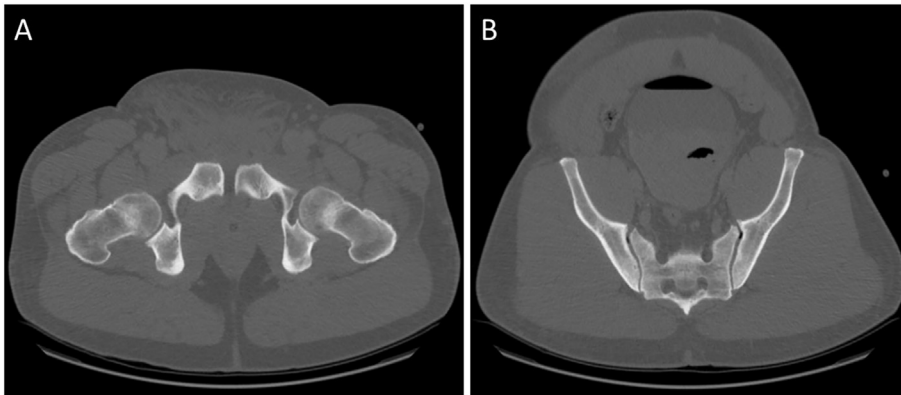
(A) Initial CT imaging showing 18 mm diastasis of the pubic symphysis. (B) Air can be seen in both sacroiliac joints.
